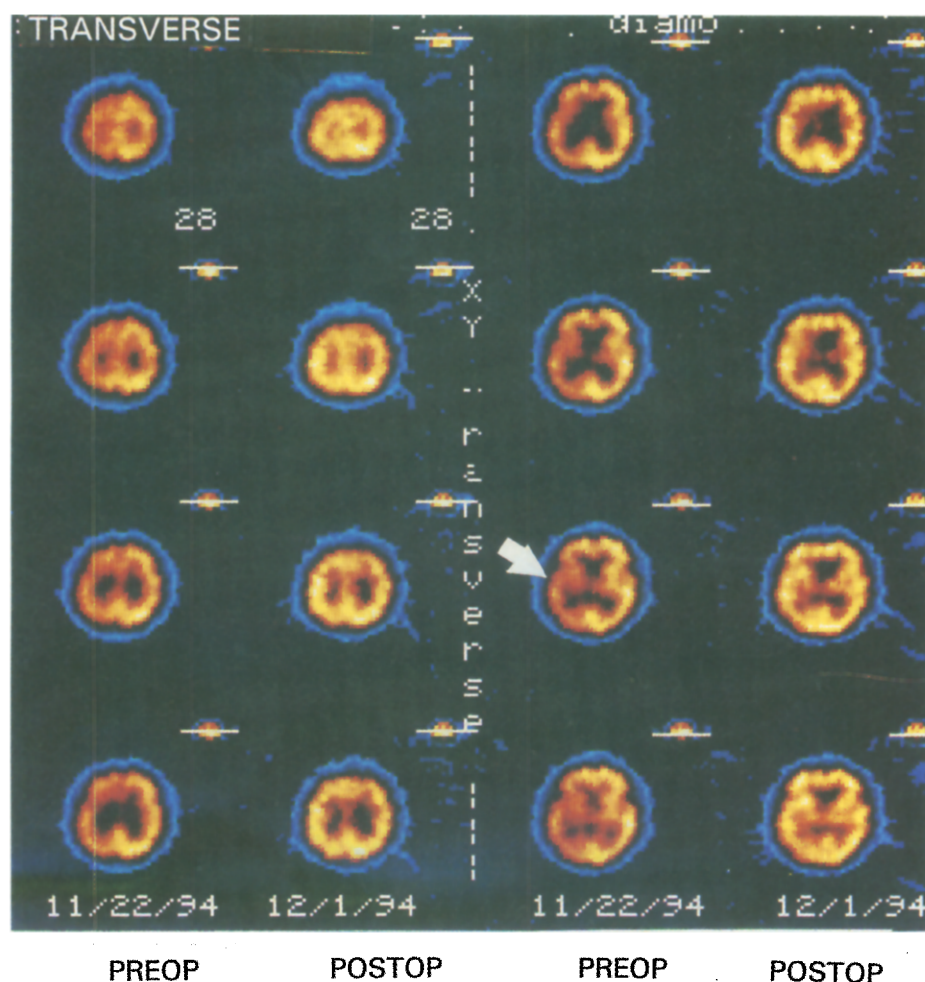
SPECT SCAN - ACZ enhancement. 80% asymptomatic right carotid stenosis. Postoperative reperfusion of (R) cortex.
